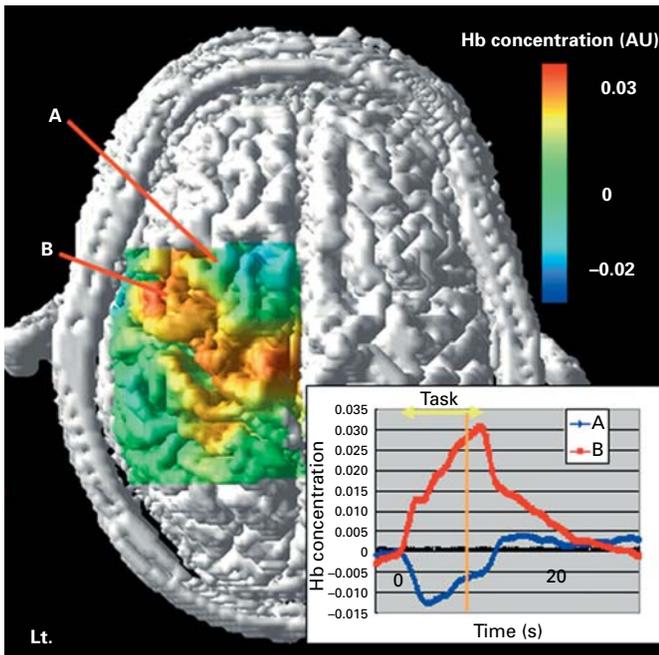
Topographic image of tHb concentration at peak activation projected onto a 3D cortical surface image reconstructed from MRI data in case 2. The tHb increase is most prominent at the center of SM1 (site B), which is easily discriminated anatomically. A decrease in tHb concentration is observed in the SM1 periphery (site A).
